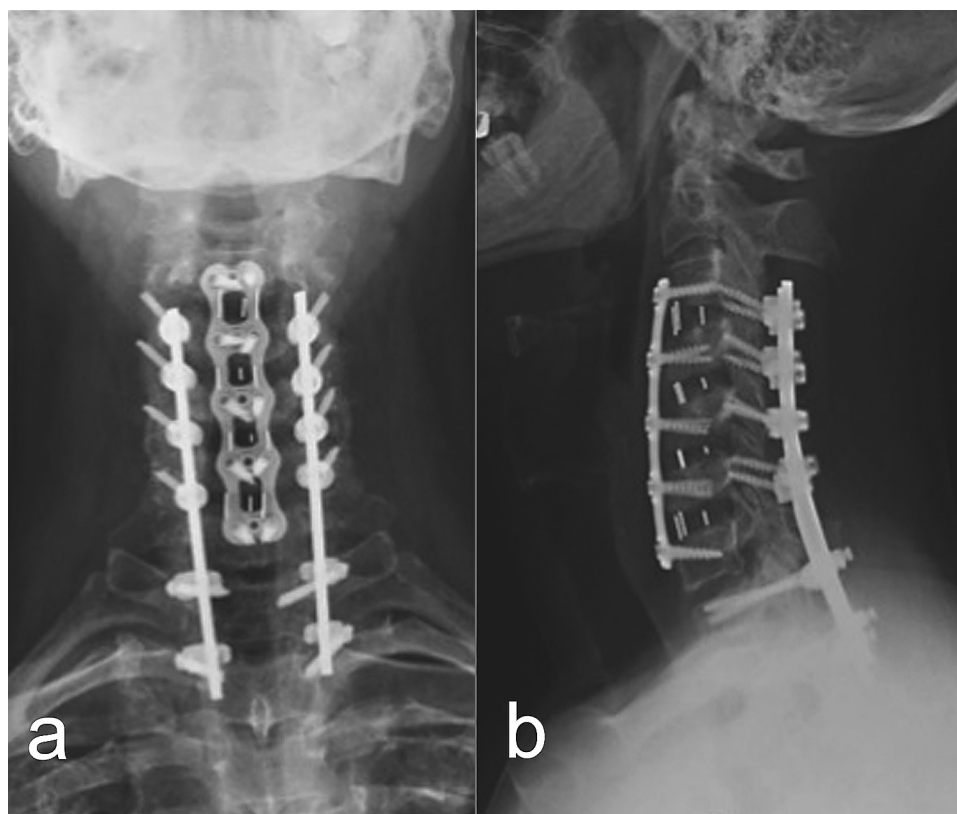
Upright neutral radiograph of the cervical spine demonstrating C3–C7 anterior cervical decompression and fusion and C3–Th2 posterior instrumented fusion: (a) antero-posterior view; (b) lateral view.
